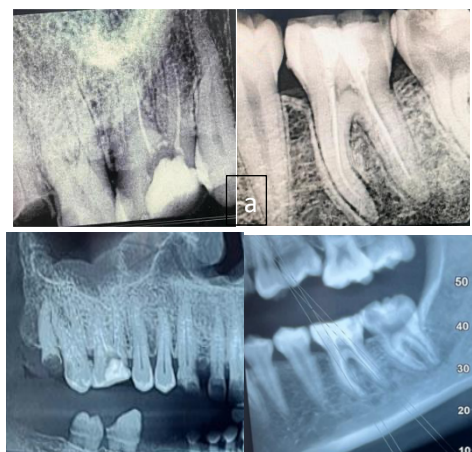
Radiographs of maxillary and mandibular molars showing RVG views and missed canal detected by CBCT of those teeth. (a) and (d) RVG in straight view; (b) and (e) RVG in 15° mesial view; (c) and (f) RVG in 15° distal view; (g) and (i) CBCT in coronal plane; (h) and (k) CBCT in axial plane; (j) and (l) CBCT in sagittal plane.
